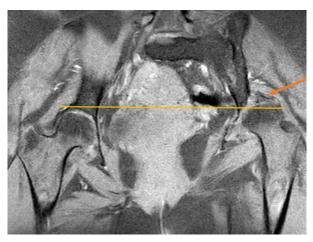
MRI of the pelvis, coronal section showing cephalic displacement of the humeral head (tomato arrow).
